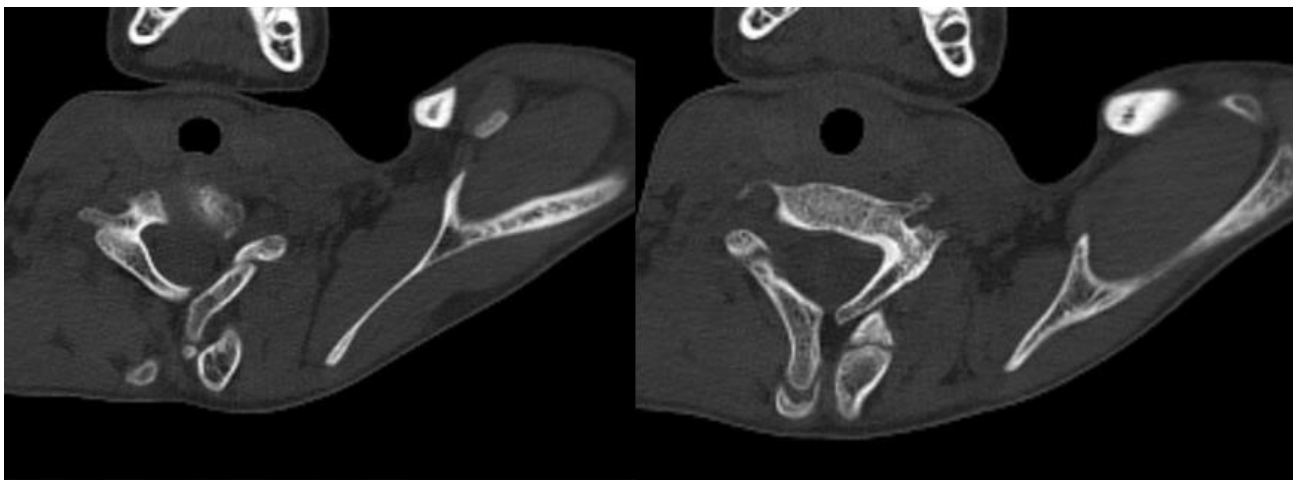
Axial slice CT images in the bone window showing a closure defect in the posterior arches of C5 and C6
